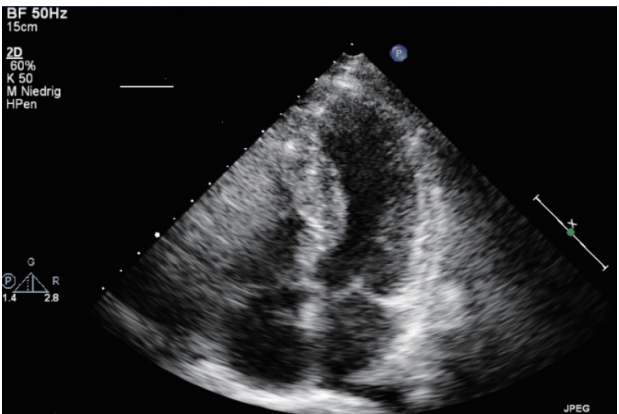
Transthoracic Echocardiography. Shown here is the typical apical four-chamber view frozen in systole with reduced left ventricular function, ejection fraction measured to 40% (Simpson) and apical akinesia.
